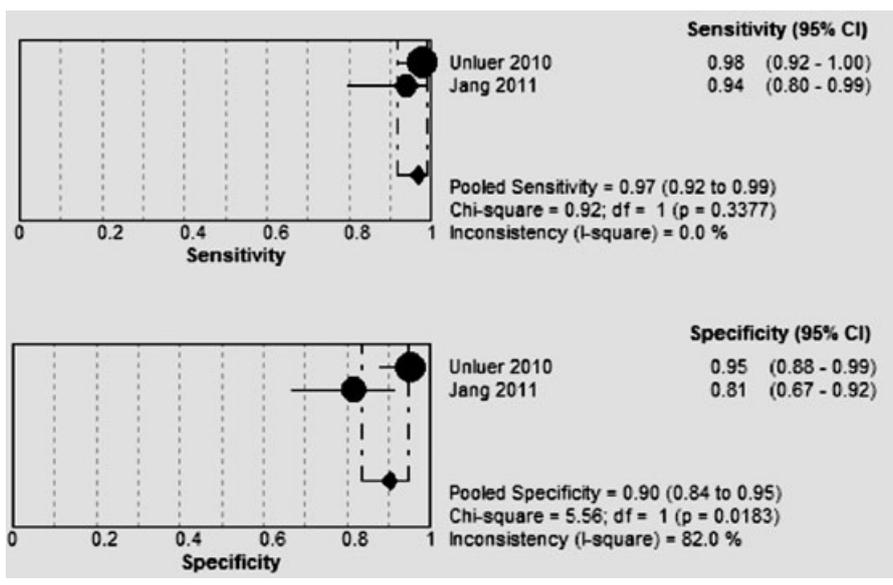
Meta-analysis of studies assessing emergency US for SBO diagnosis. SBO = small bowel obstruction; US = ultrasound.
